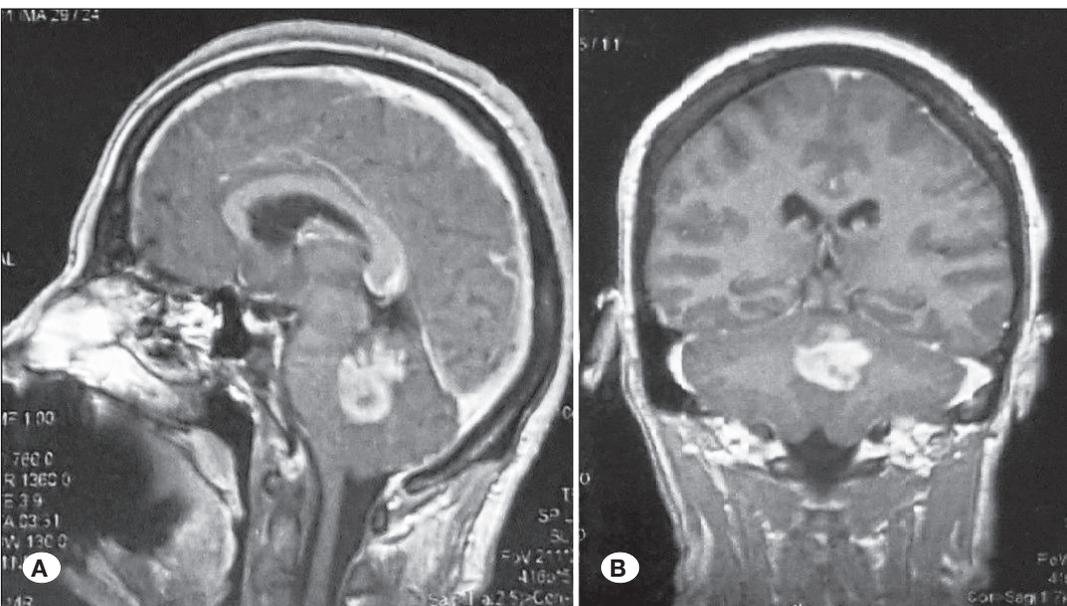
Case 7 - posterior fossa ganglioglioma. Preoperative sagittal (A) and coronal (B) T1W contrast enhanced MRI scans. Midline contrast enhancing vermian tumor.
